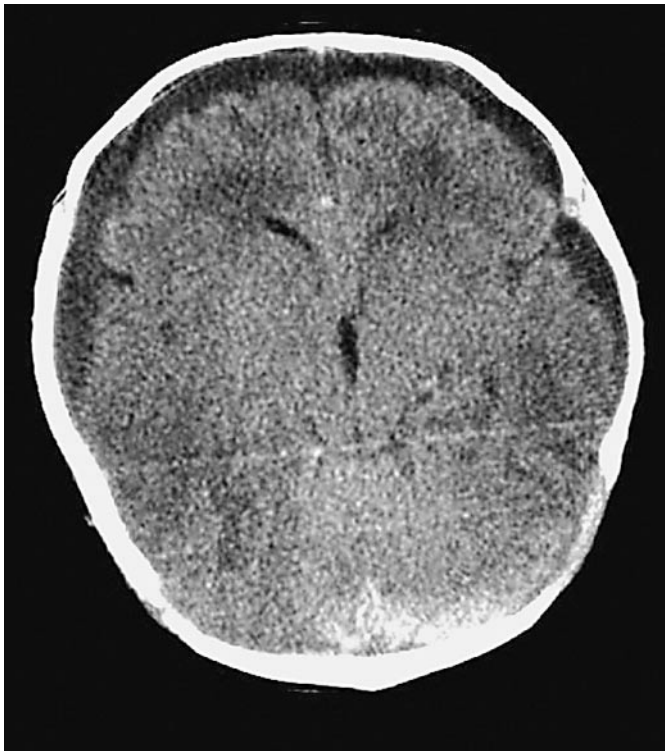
Noncontrast head CT shows bilateral subdural collections, falcine subdural hematoma, and traumatic subarachnoid hemorrhage (with permission from Mayfield Clinic).
